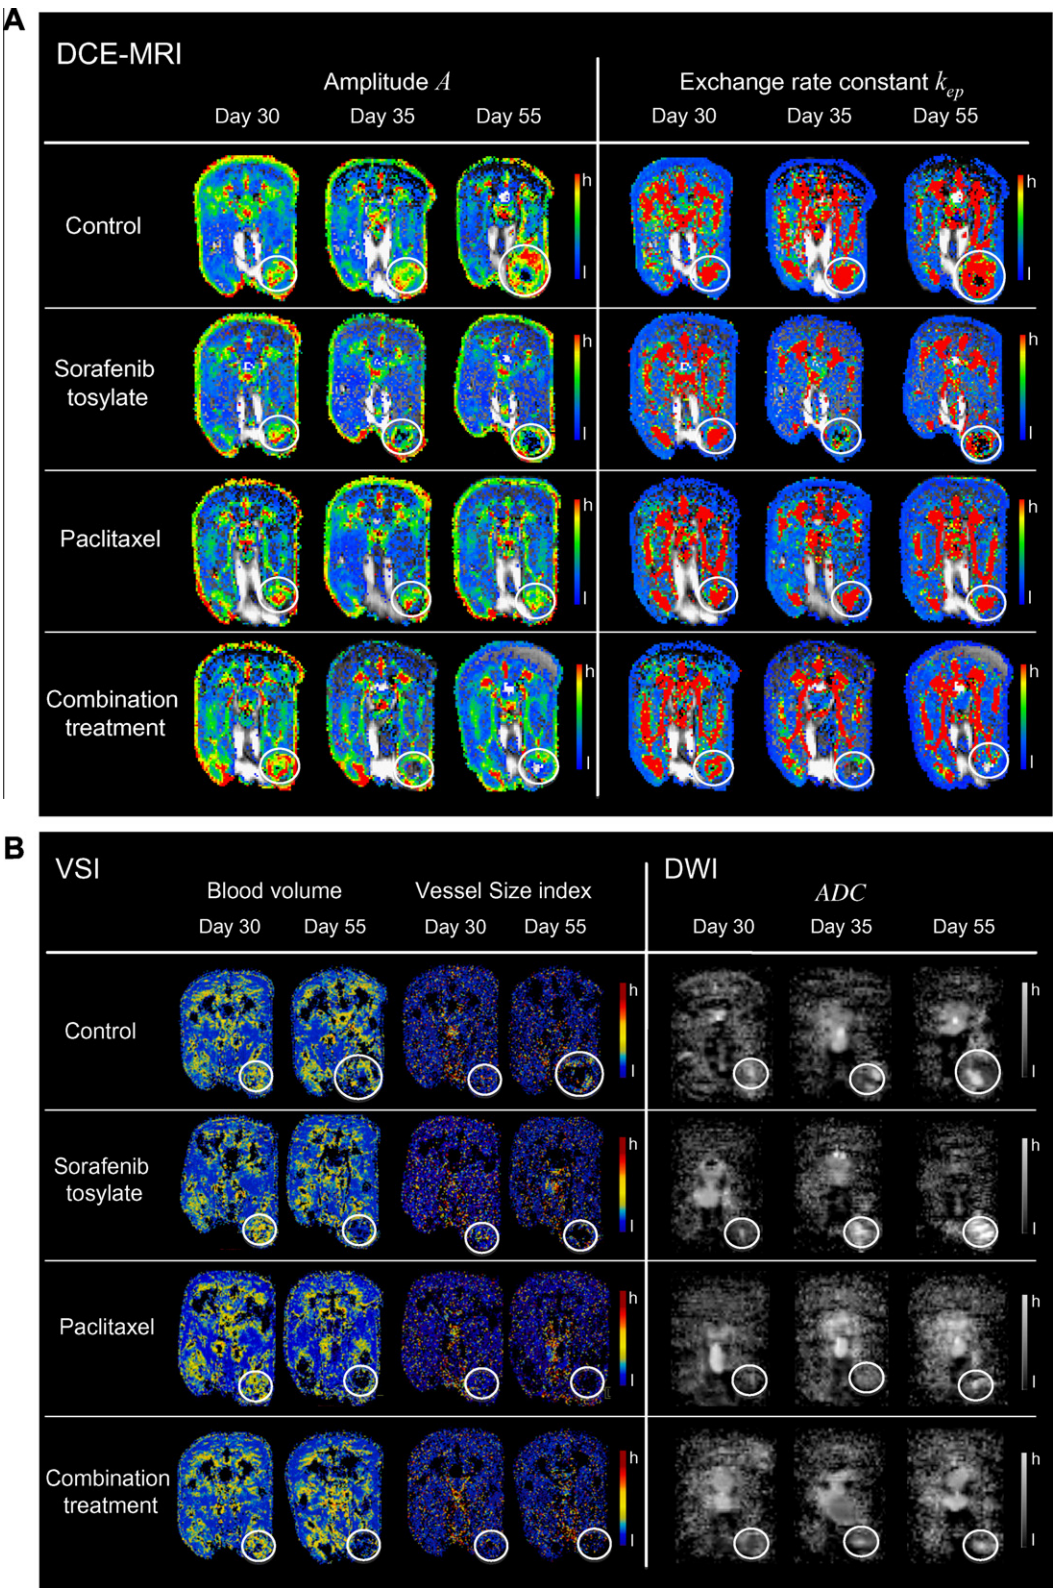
Colour maps of experimental breast cancer bone metastases as imaged by DCE-MRI, VSI and DWI. (A) DCE-MRI colour maps of amplitude A (left side) and exchange rate constant k_{ep} (right side) on days 30, 35 and 55 after tumour cell inoculation with values ranging from high (h) in red to low (l) in blue. (B) VSI colour maps of blood volume and vessel size index (left side) on days 30 and 55 after tumour cell inoculation ranging from high (h) values in red to low (l) values in blue. ADC maps from DWI (right side) on days 30, 35 and 55 after tumour cell inoculation ranging from high (h) values in white to low (l) values in black. All maps are presented in axial orientation; white circles delineate bone metastases.
